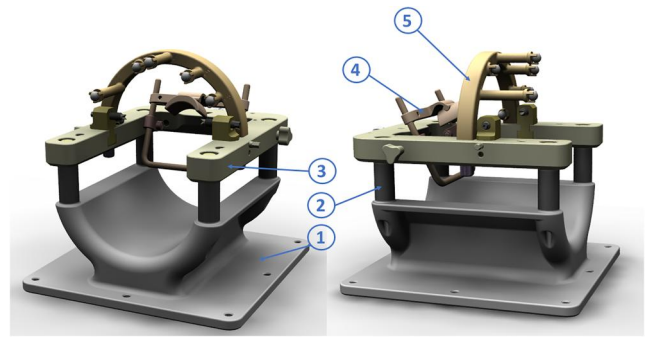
Rendering of the new head frame system with arc fiducials for MR/CT registrations
